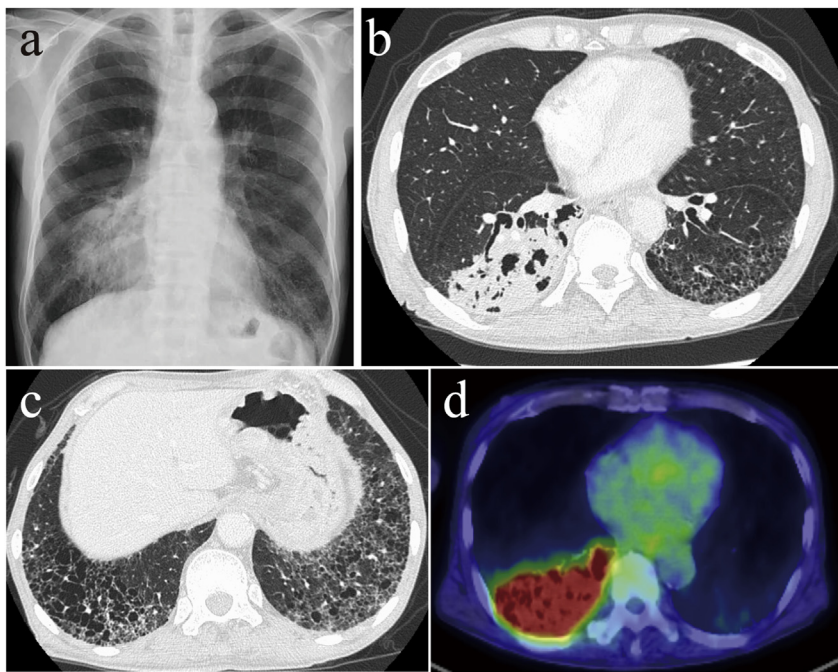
Chest radiograph shows an irregular opacity in the lower lobe of the right lung (a). Chest computed tomography (CT) scan shows a large area of consolidation with air bronchogram in the right lower lobe and reticular opacities with honeycombing in both lungs (b, c). 18F-fluorodeoxyglucose positron emission tomography (FDG-PET)/CT shows increased uptake (maximum standardized uptake value of 13.03) in the right lung lesion (d).
